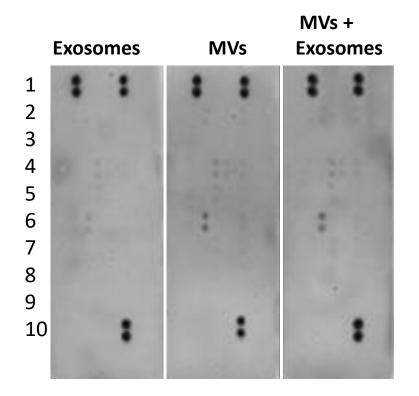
Cytokine array showing the expression of 36 growth factors cytokines and acute phase proteins in samples of MV and exosomes. Samples were lysed with Triton X-100 and placed on the cytokine microarrays. Membranes were processed as described by the manufacturers, essentially by exposing the membranes with lysed MVs and exosomes to the detection antibodies, chemiluminescent signals being developed by exposure to the substrate luminol. Microarrays were then and developed by 10 mins exposure to X-ray film. Controls are the two duplicate dots of high intensity in row 1 and the one duplicate dot in row 10.
